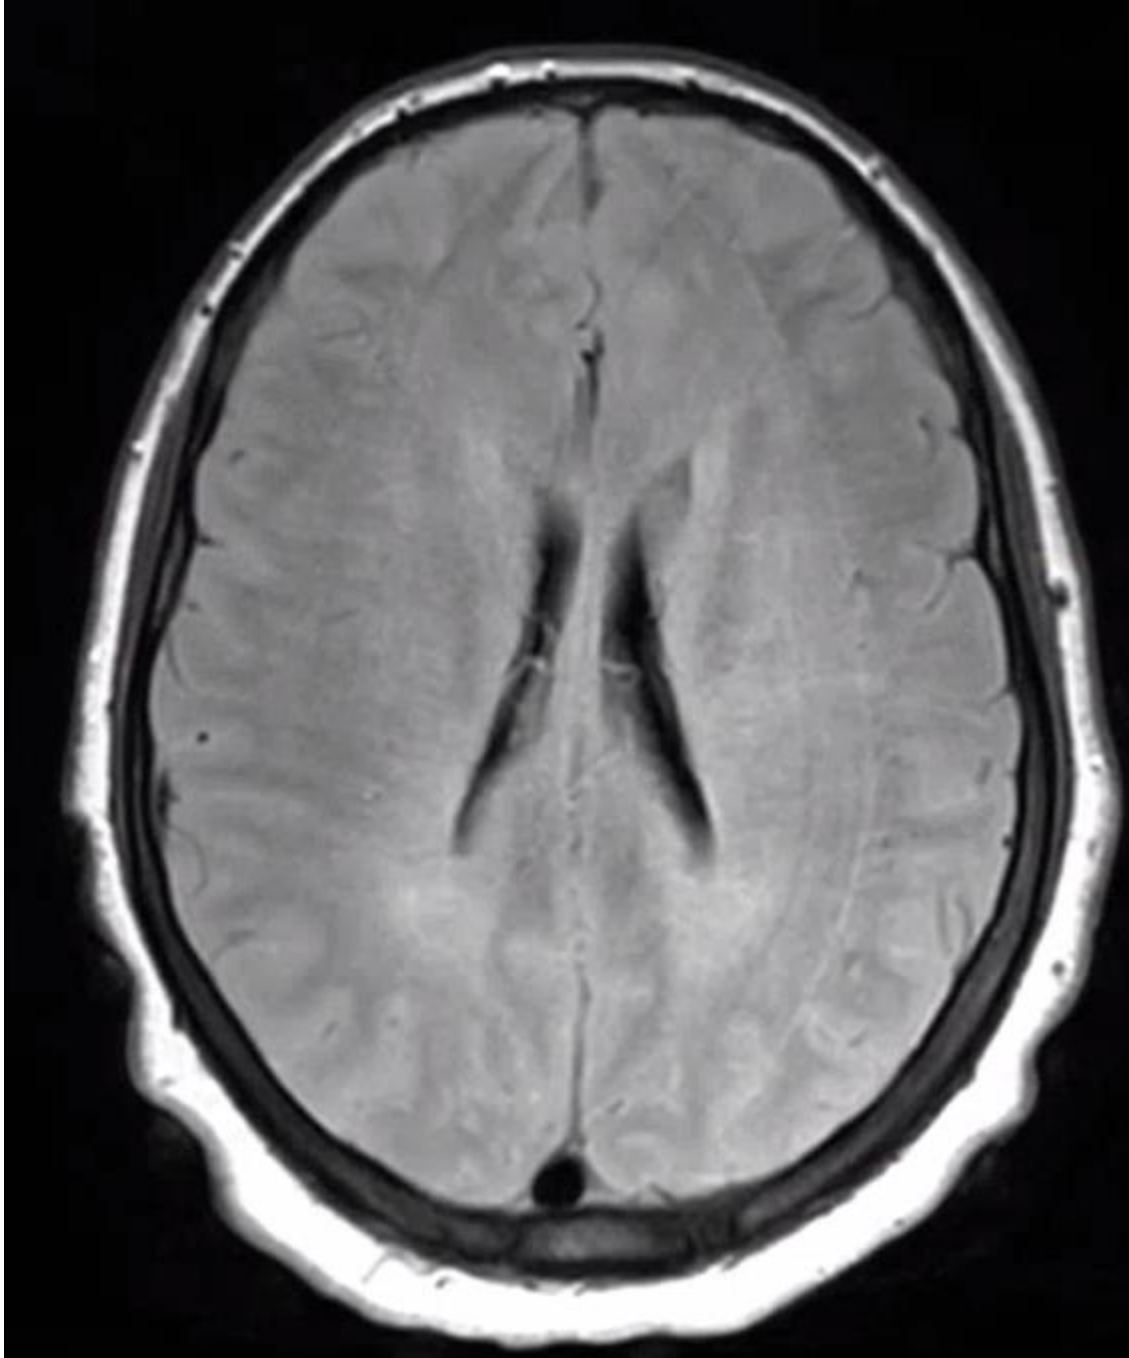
MRI T2 axial flair view of exhibiting T2 hyperintensities of the periventricular white matter, external capsule, and corpus callosum
